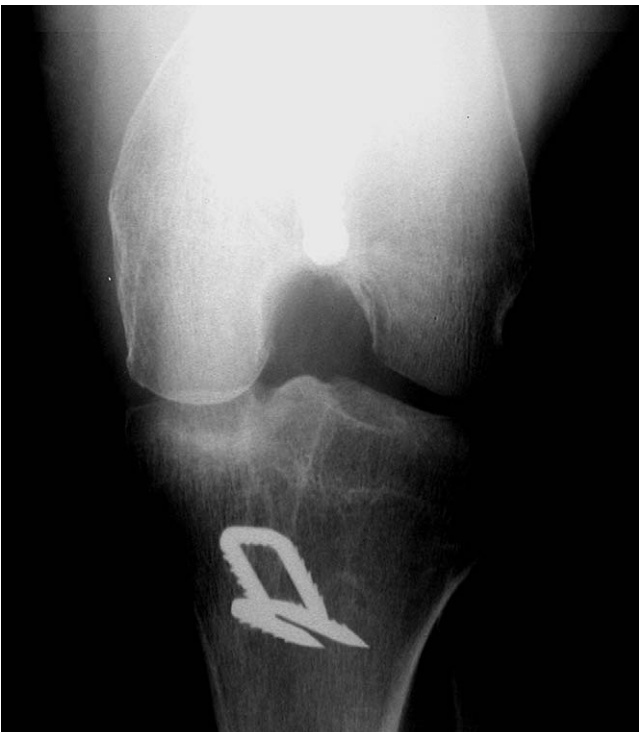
Anteroposterior radiograph demonstrating vertical malpositioning of the femoral footprint and tunnel.
